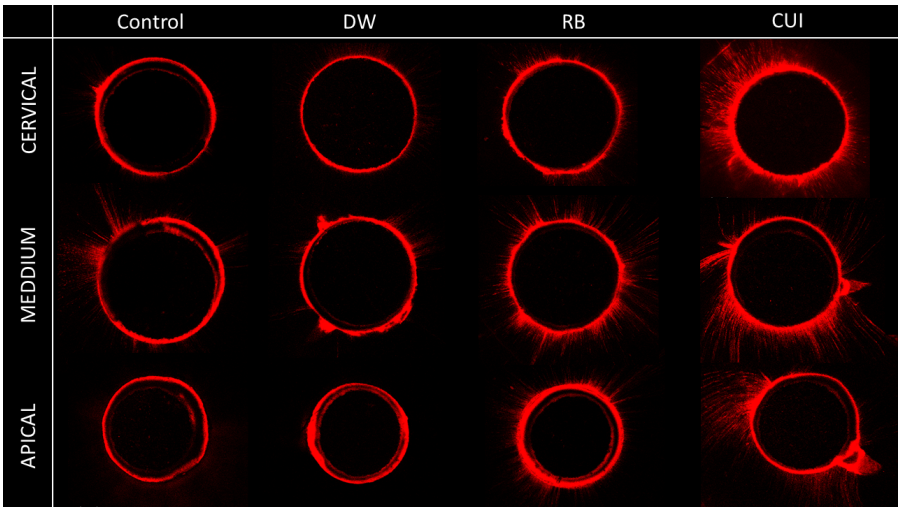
Representative image of dentinal penetration of the cementation system, depending on the thirds and cleaning protocols of the post space. Abbreviations: CI, conventional irrigation; CUI, continuous ultrasonic irrigation; RB, rotating brush. Scale: 100x. 600  $\mu$ m.
